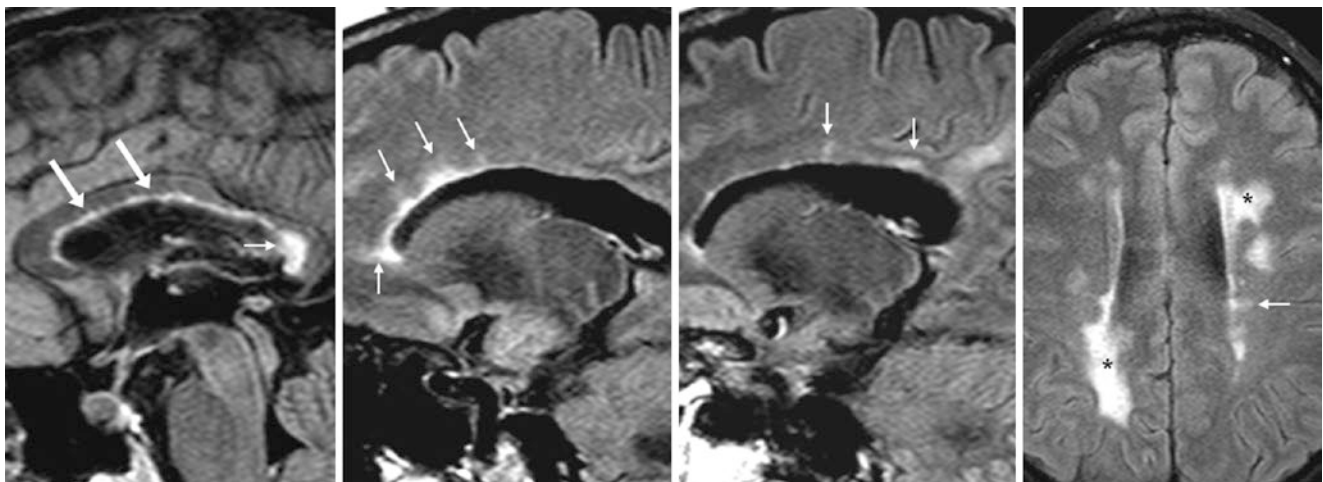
Comparison case of a patient with multiple sclerosis (MS). A 37 year old with worsening disease had normal hyperintense signal anteriorly at the callosal-septal interface (*arrows*) on a midline sagittal FLAIR image (*left*), but there was an irregular margin posteriorly; a focal lesion was noted within the splenium (*tiny arrow*). More laterally
